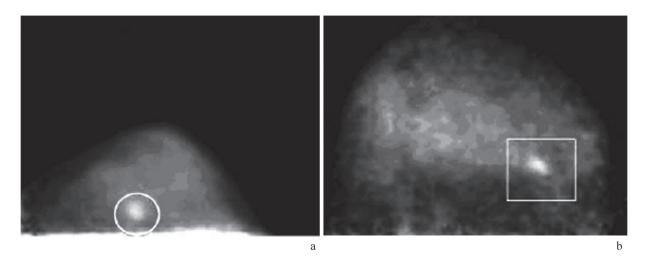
Demonstration of small invasive breast carcinomas with FDG PEM. Images from dedicated breast PEM units show 9-mm (circle in a) and 1.3-cm (rectangle in b) invasive carcinomas. (RadioGraphics 2007; 27:S215-S229)
